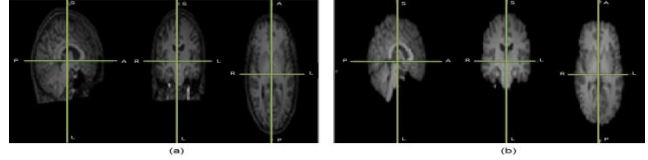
An example of the brain MRI registration with an original MR image of brain (a) and registered image (b).
